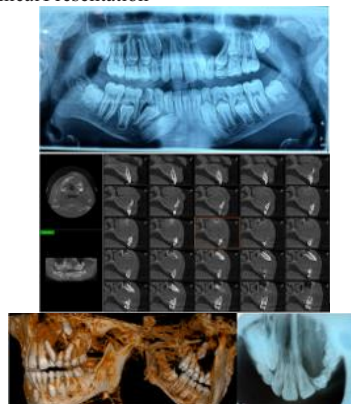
radiographic examination
